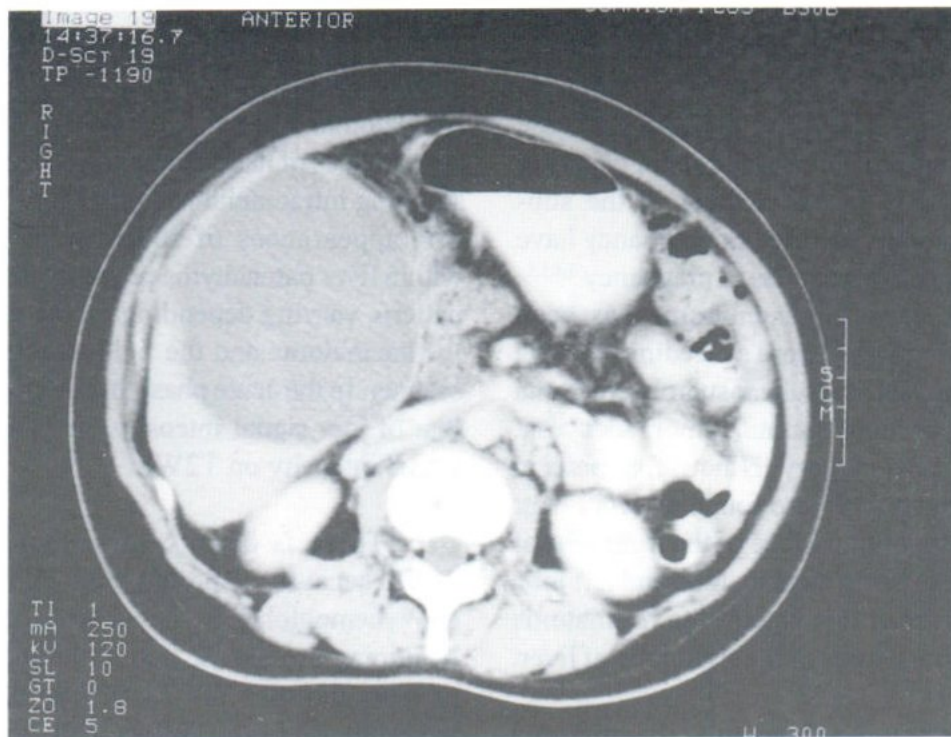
CT abdomen (axial) shows a non enhancing homogenous collection. The liver appears deformed.
